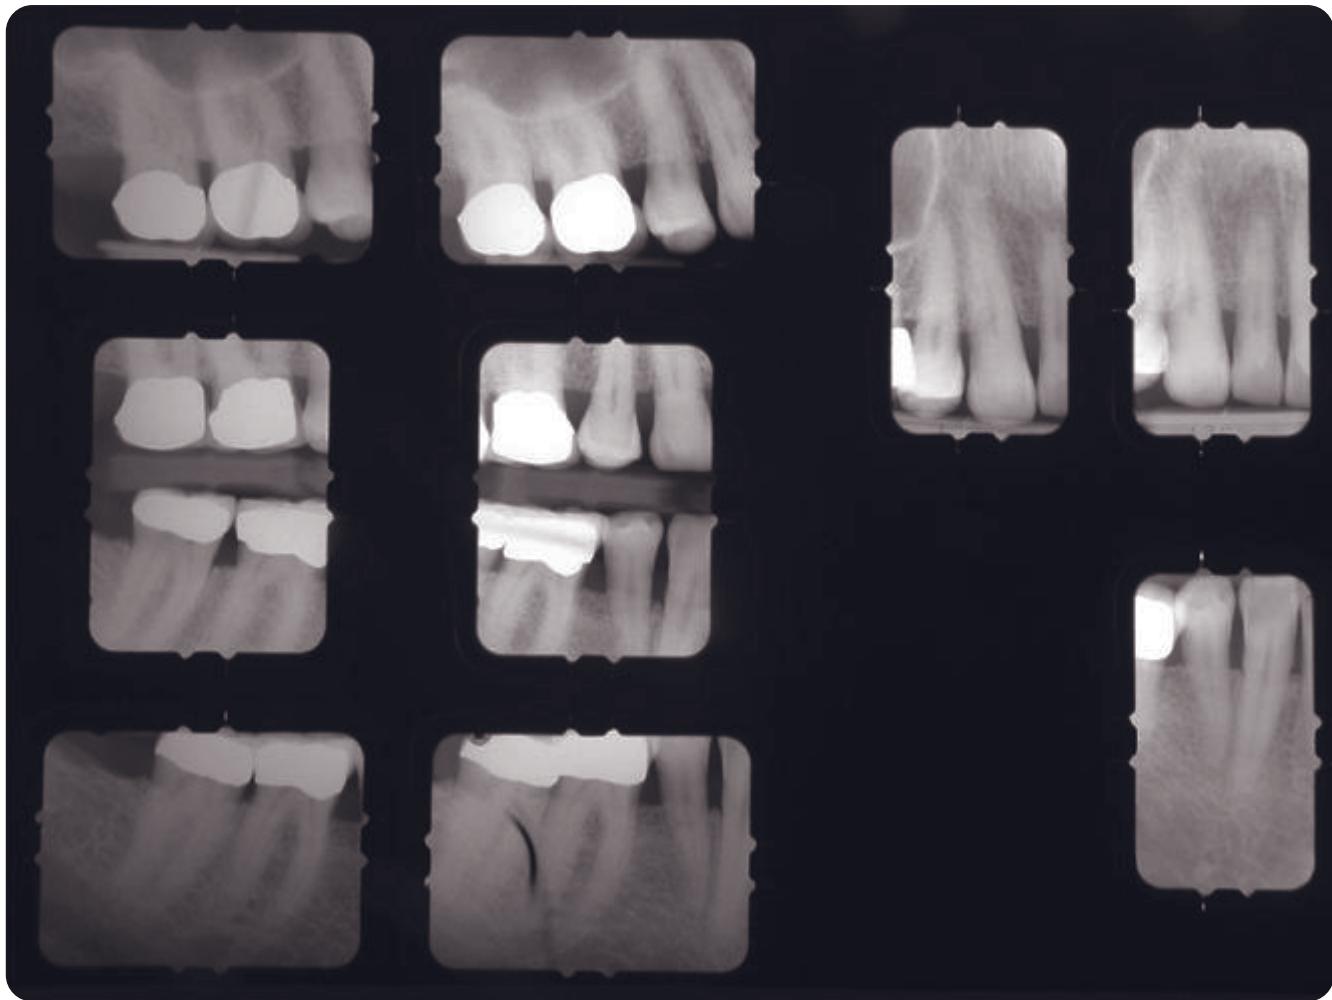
Posttreatment radiographs of the completed restorations, right side.
